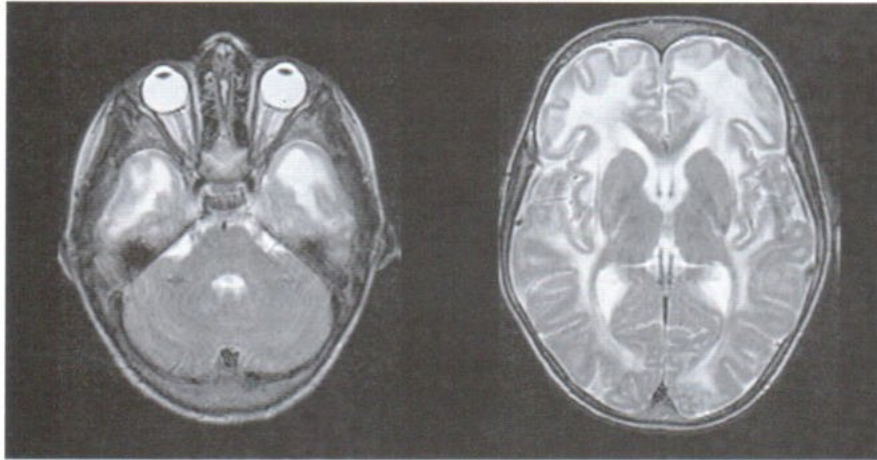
Axial T2-weighted (TR.3000 ms/TE.105 ms) images show diffuse T2 prolongation of the cerebral white matter predominantly at the frontotemporal lobes with anterior temporal subcortical cysts. Note increased T2 prolongation of the dentate nuclei (asterisk) and dorsal pons (black arrow).
